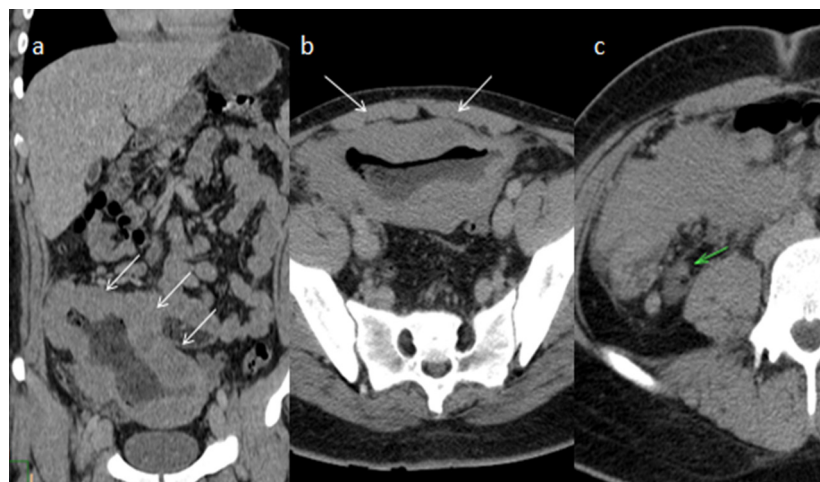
Contrast-enhanced abdominal CT coronal (A) and axial (B) images show aneurysmal dilatation and minimally enhancing mural thickening in terminal ileal segment. In retrocaecal region, appendix vermiformis diameter is in normal limits (6 mm) with minimal periappendiceal fluid (C).
